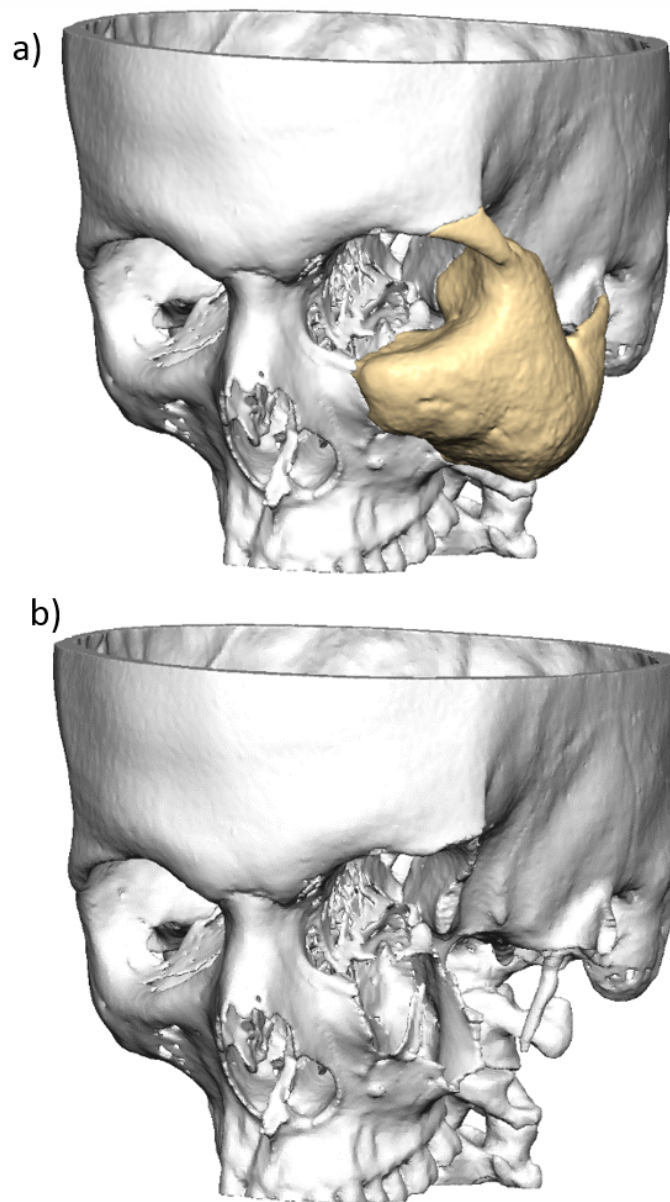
a) Preoperative CT image of the patient, b) Anatomical model of the face with lesion produced using AM
